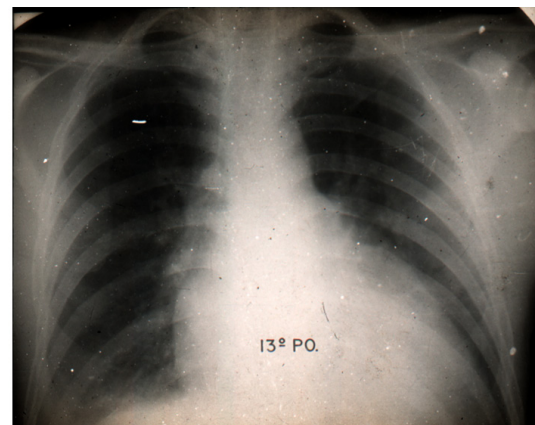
Radiography of João “boiadeiro” at the 13th postoperative day.
